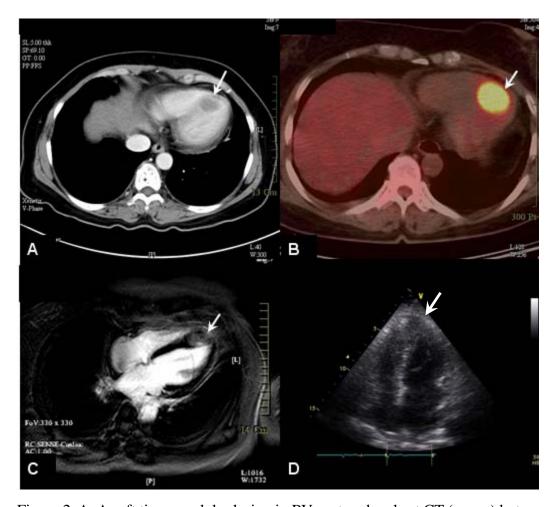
A: A soft tissue nodular lesion in RV septum by chest CT (arrow) but ignored initially, B: A hypermetabolic lesion in RV septum by PET/CT (arrow), C: A nodule with isointensity to myocardium of the RV septum (arrow), D: TTE showed focal apical inferoseptal and inferior myocardial wall thickness (arrow)
